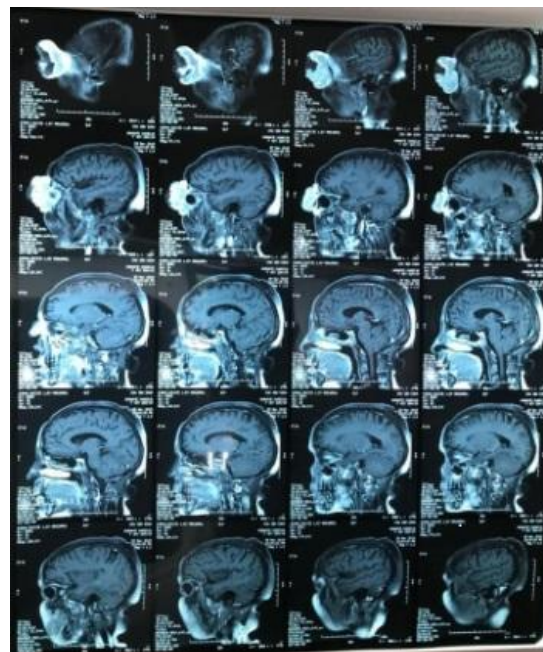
Images of orbital MRI
